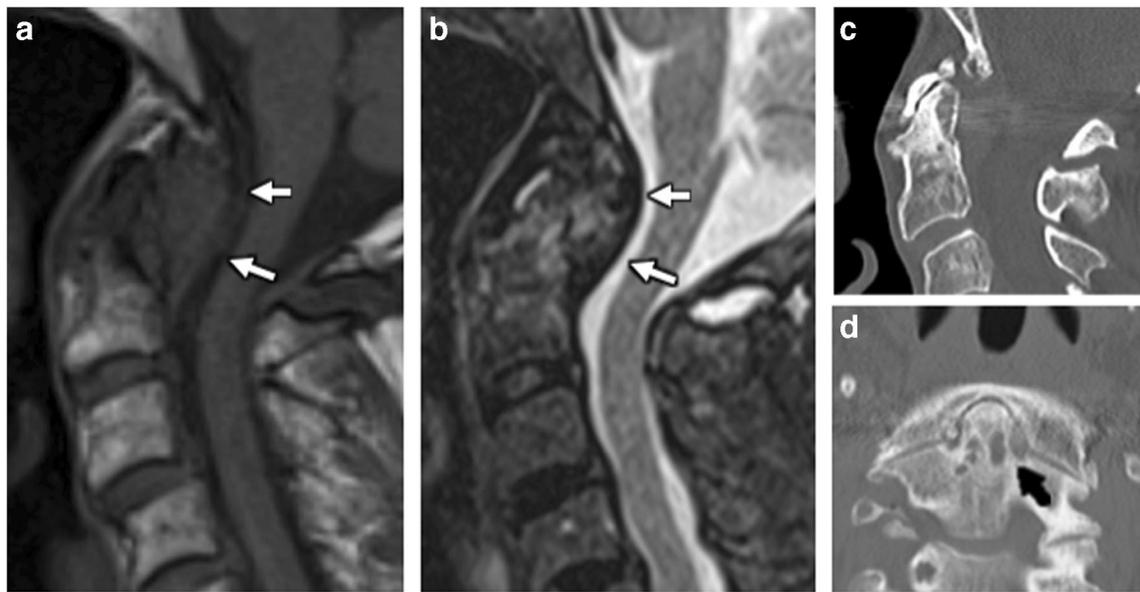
a A 67-year-old woman with mixed signal intensity pseudotumor and erosive bony change from a non-rheumatoid etiology, differential includes CPPD, PVNS, gout, osteoarthritis, or hemodialysis-associated amyloidosis. Sagittal T1-weighted MR demonstrates T1 isointense soft tissue (arrows) posterior to the dens. b Sagittal T2-weighted image shows
